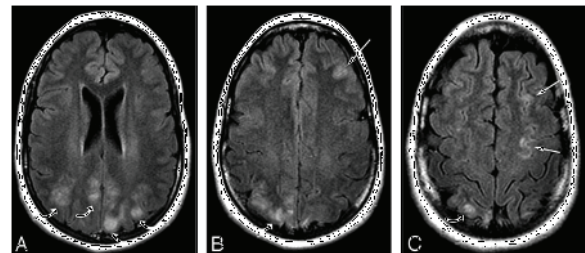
MRI - Hypointense area seen predominantly in parieto-occipital lobes and minimally in frontal region
